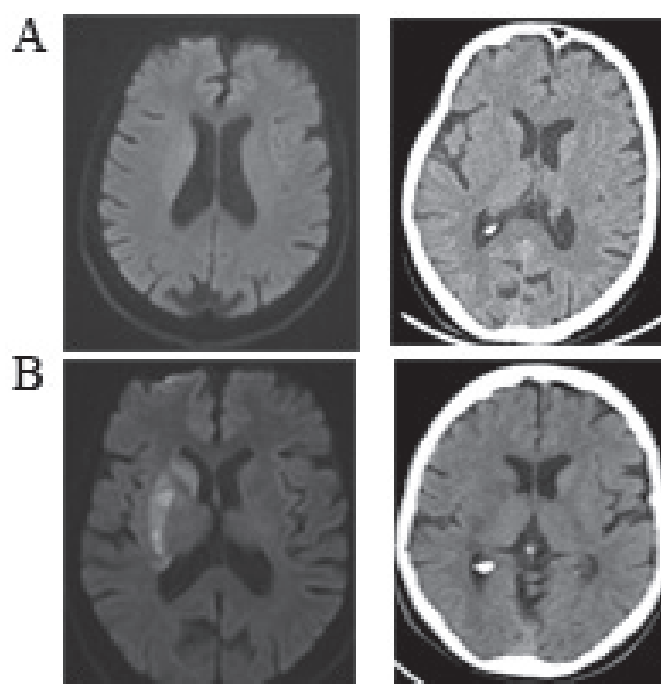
A) Pre-operative MRI and CT B) Post-operative MRI and CT
